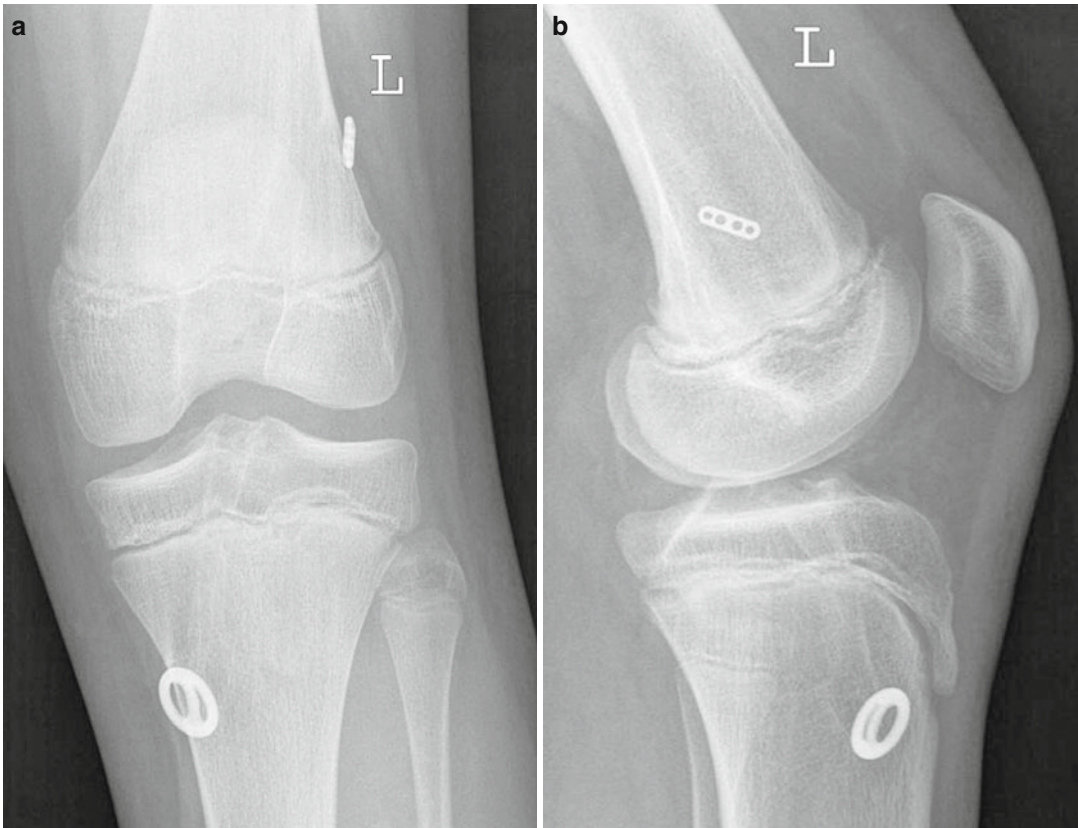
(a, b) X-rays 2 years postoperative
